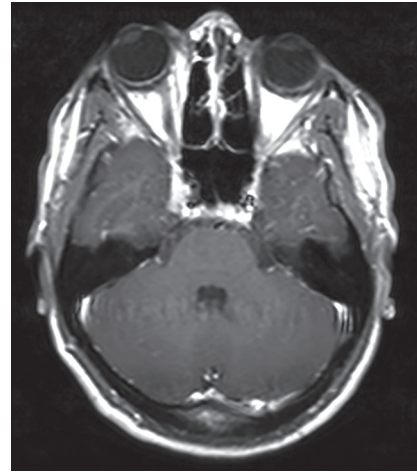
Contrast-enhanced T1-weighted image, 1st-year control
